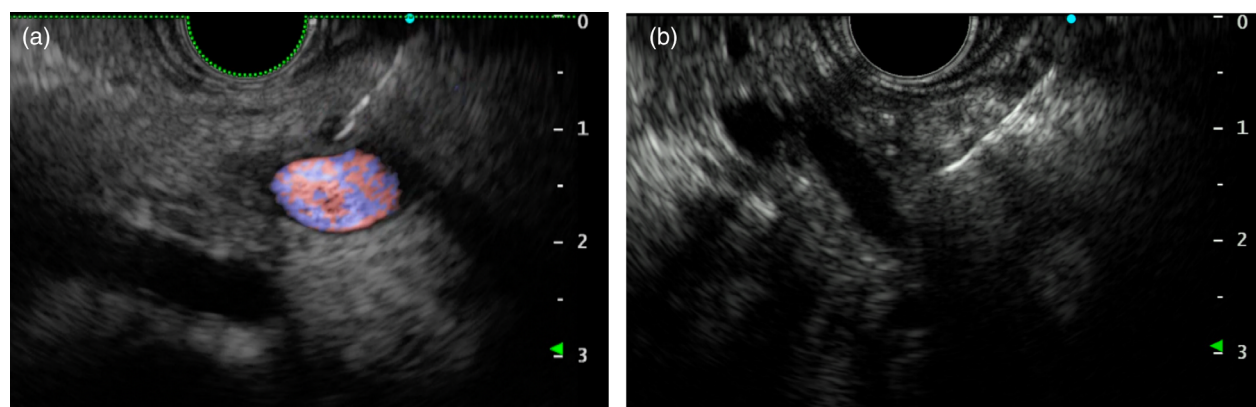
Endoscopic ultrasound-guided tissue acquisition for perivascular soft-tissue cuffing around celiac artery in patients with (a) a puncture length of 3 mm or (b) a puncture length of 6 mm.
